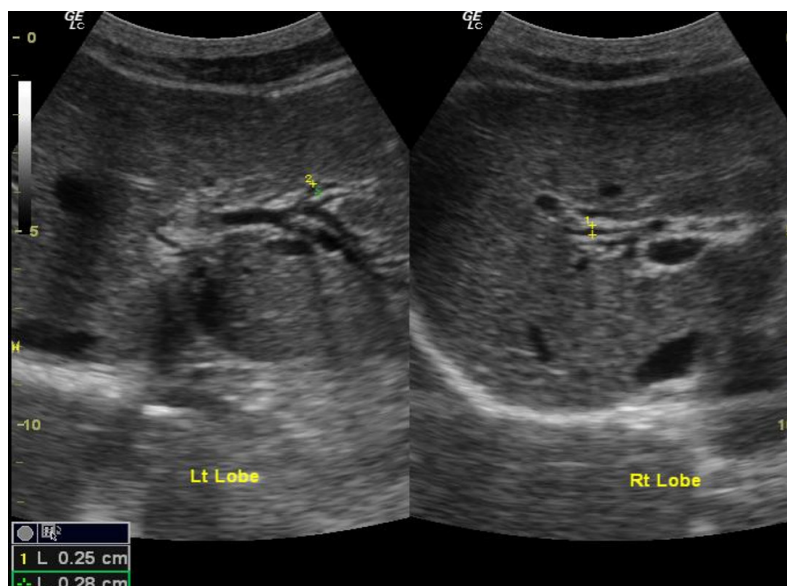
Sonographic Image Depicting Diffuse Bile duct Dilatation, Revealing Visible Tubular Structures adjacent to the Portal Vein of the Left and Right Hepatic Lobes, respectively.
